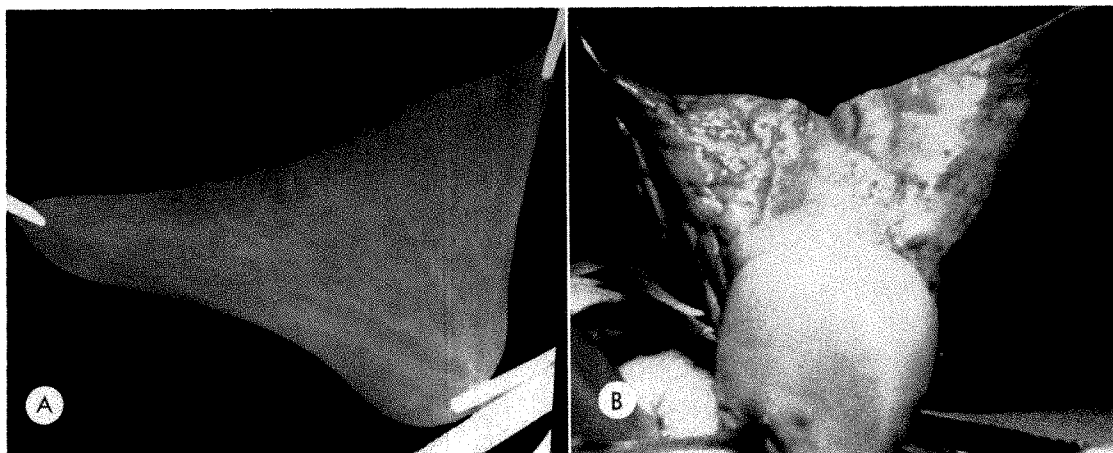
Roentgenogram (*A*) and photograph (*B*) demonstrate total aeration of one segment and beginning inflation of the other segments. This degree of aeration followed within one minute of cycled ventilation at 40 cm. of water pressure through a single patent segmental bronchus.
